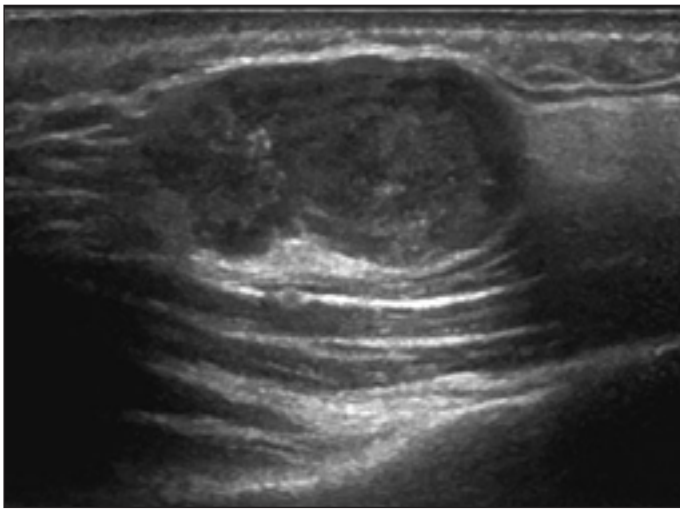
Longitudinal ultrasound image of the left parotid gland (same patient as Figure 1) confirms a focal, lobulated hypoechoic lesion demonstrating central mixed echotexture. This corresponds with the area of increased positron emission tomography activity, and biopsy confirmed a diagnosis of Warthin's tumour.
